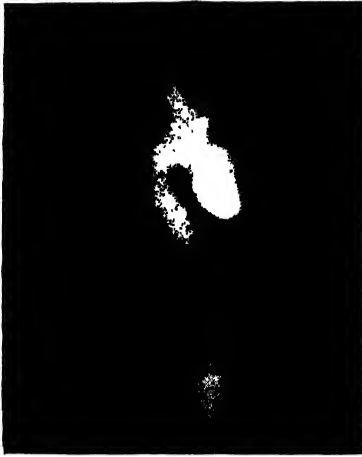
Semi-lateral radiograph of a pouch after barium has been swallowed.
